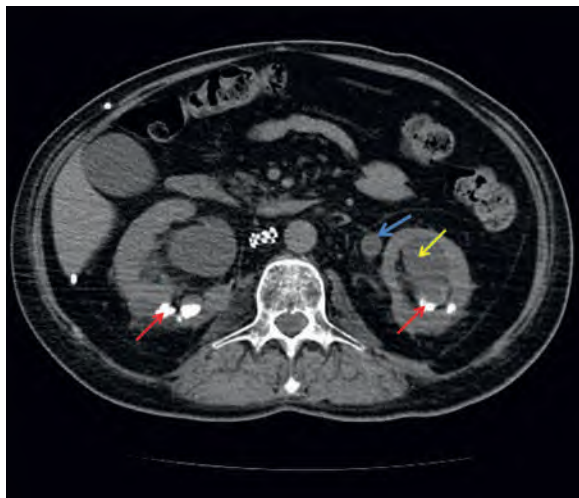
Unenhanced computed tomography scan of the abdomen in a spinal cord-injured patient with a chronic indwelling bladder catheter and repeated episodes of upper and lower urinary tract infection due to *Proteus mirabilis*. Note bilateral kidney stones (red arrows), left hydronephrosis (yellow arrow), and left hydroureter (blue arrow).
